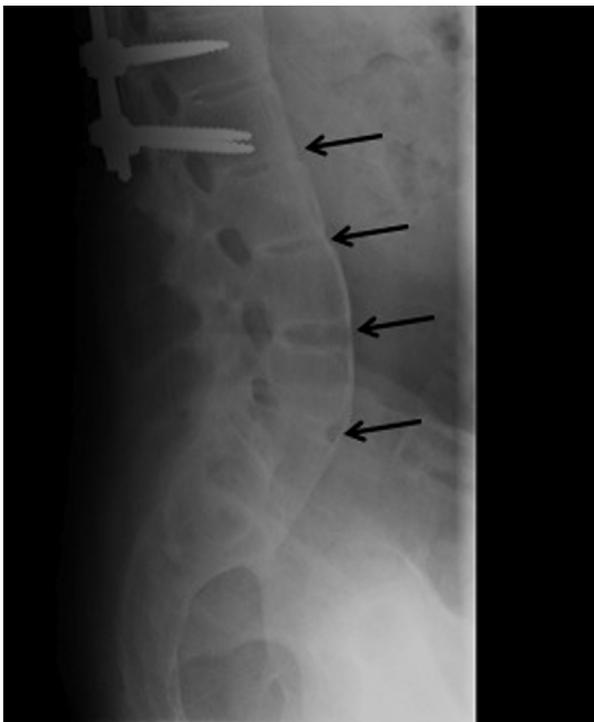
Plain film in a patient with a diagnosis of ankylosing spondylitis. Plain films of the lumbar, thoracic, and cervical spine can demonstrate syndesmophytes (arrows) in patients with ankylosing spondylitis. Syndesmophytes represent calcified spinal ligaments and annulus fibrosus.
